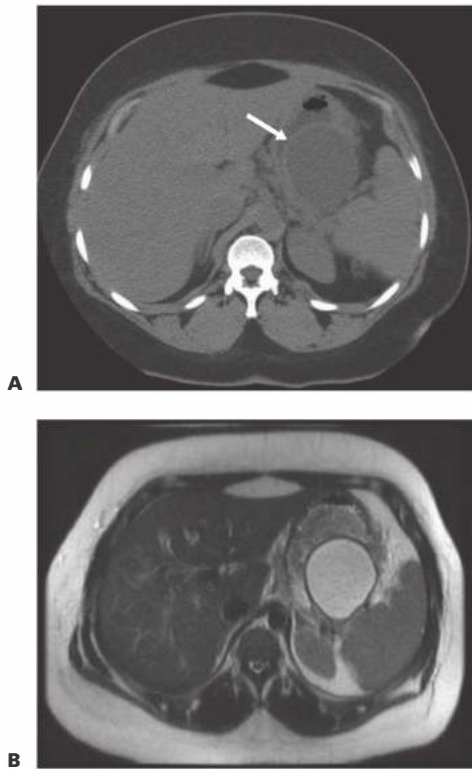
• Pancreatic pseudocyst. A. A homogeneous fluid collection is surrounded by a discrete wall that is apparent despite the absence of intravenous contrast. B. Magnetic resonance imaging confirms the absence of solid material (necrotic debris) within the pseudocyst.
